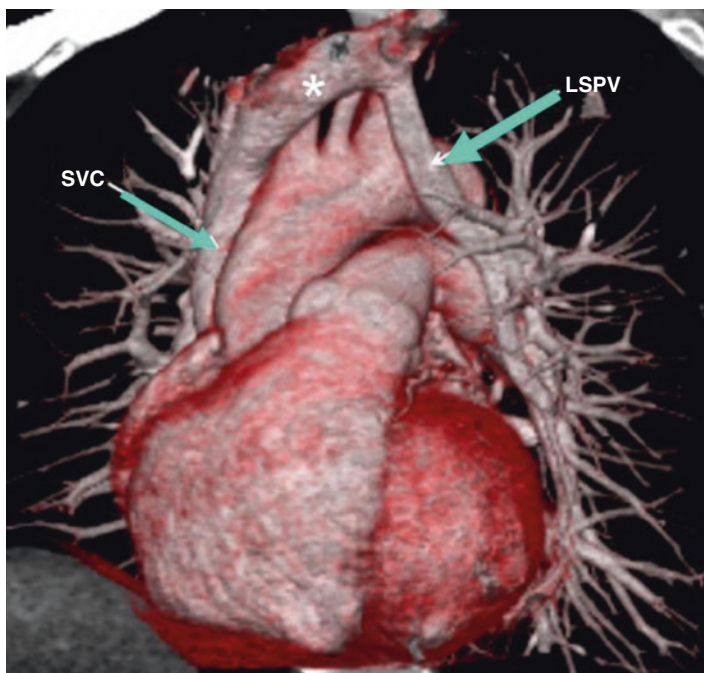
Three-dimensional CT angiography of anomalous left upper pulmonary venous drainage to the innominate vein
